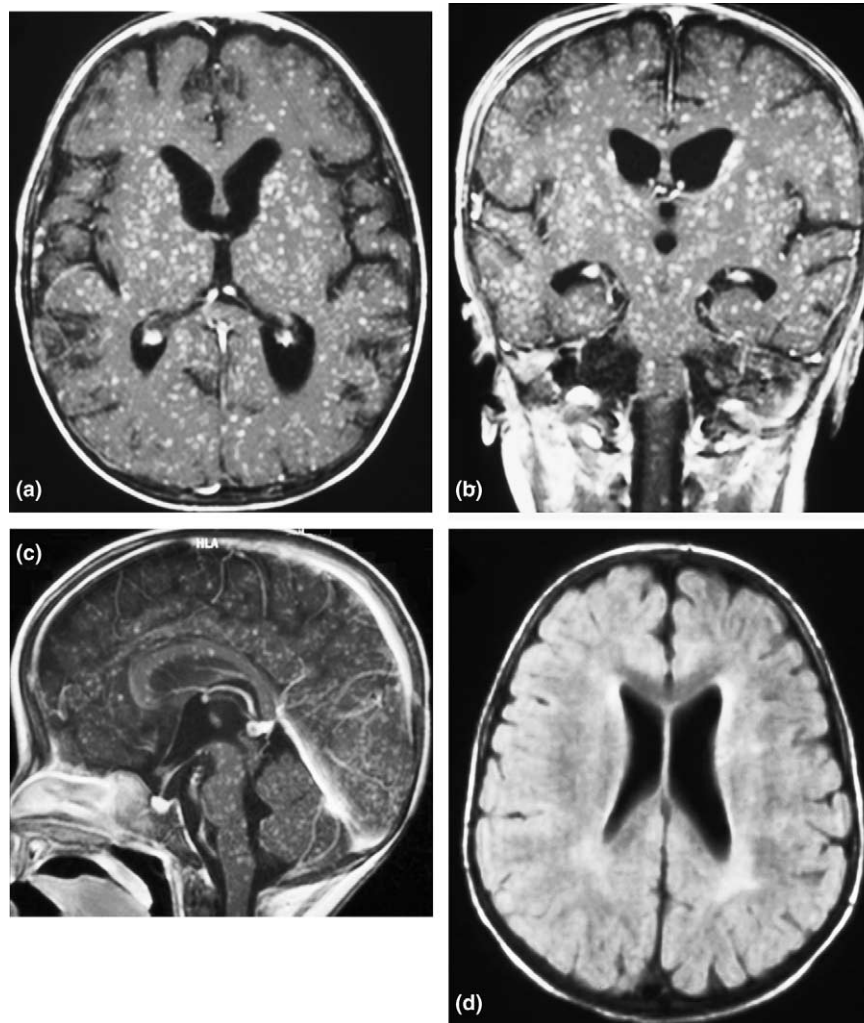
Case 22: 1-year-old girl with presumed *Aspergillus* infection. (a)–(c): T1-weighted MR images after contrast show disseminated enhancing nodules in the brain and cerebellum. (d): Follow-up MRI after 5 months showed complete resolution of the cerebral lesions.
